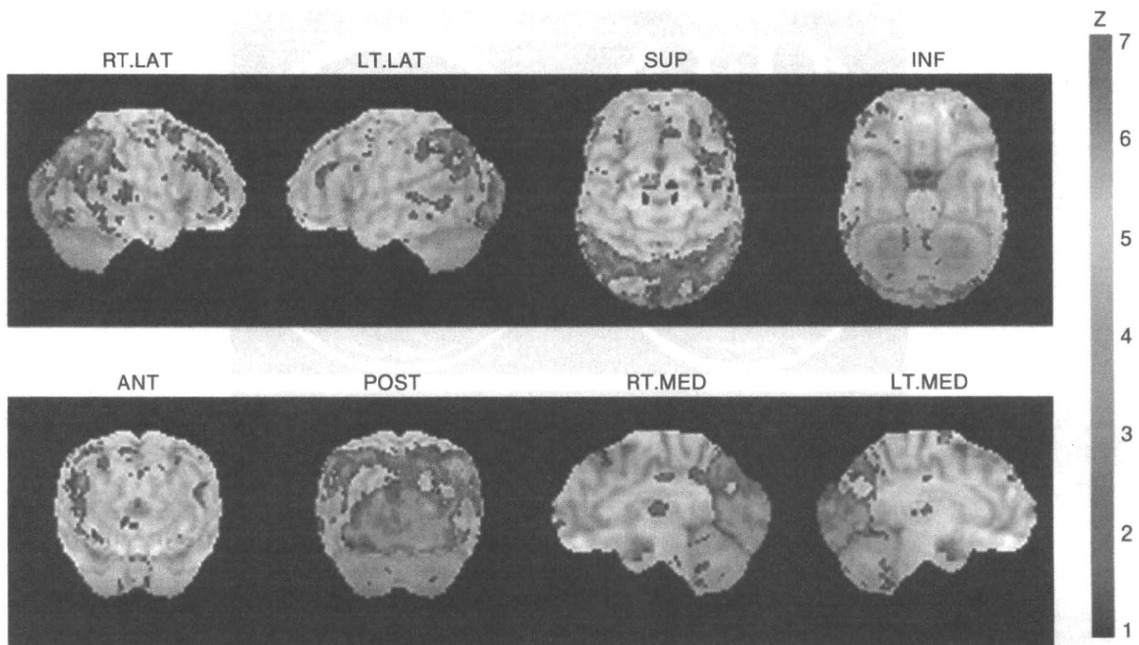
頭部 ^{18}F -FDG PET 画像
